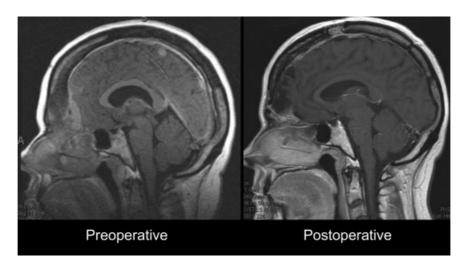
Preoperative and 29-month postoperative sagittal contrast-enhanced magnetic resonance imaging of the head demonstrating postoperative absence of dural enhancement and expansion of the cerebrum into the space previously occupied by tumorous bone.
